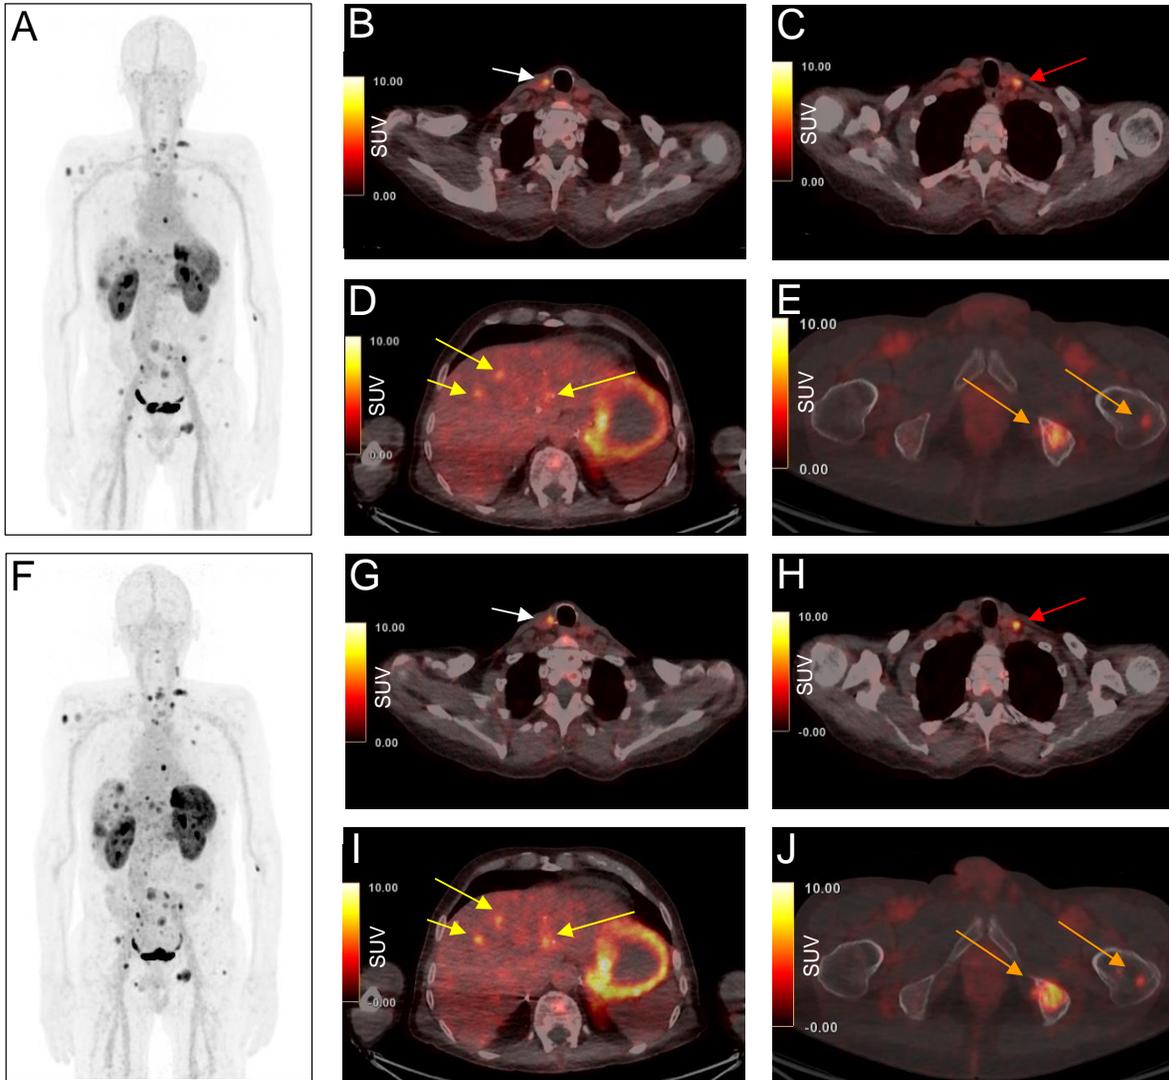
Maximum intensity projection and axial fused  $^{68}\text{Ga}$ -DOTA-MGS5 PET/CT images one hour (a-e) and two hours p.i. (f-j) of a metastatic MTC patient (calcitonin:  $>2000$  ng/L), showing local recurrence on the right paratracheal region with  $\text{SUV}_{\text{max}}$  of 7.8 vs. 8.5 at 1 and 2 h p.i. (b, g; white arrow), cervical lymph node metastasis with  $\text{SUV}_{\text{max}}$  of 7.1 vs. 8.1 (as depicted on the left cervical region in c and h; red arrow), several liver metastases with  $\text{SUV}_{\text{max}}$  of 5.5, 6.3, 5.3 vs 6.7, 7.1, 6.7 (d and i; marked with yellow arrows) and multiple bone metastases with  $\text{SUV}_{\text{max}}$  in two lesions of 7.6, 3.6 vs 9.7, 5.1 (as demonstrated, in the left iliac bone and left femur on e and j; orange arrows).
